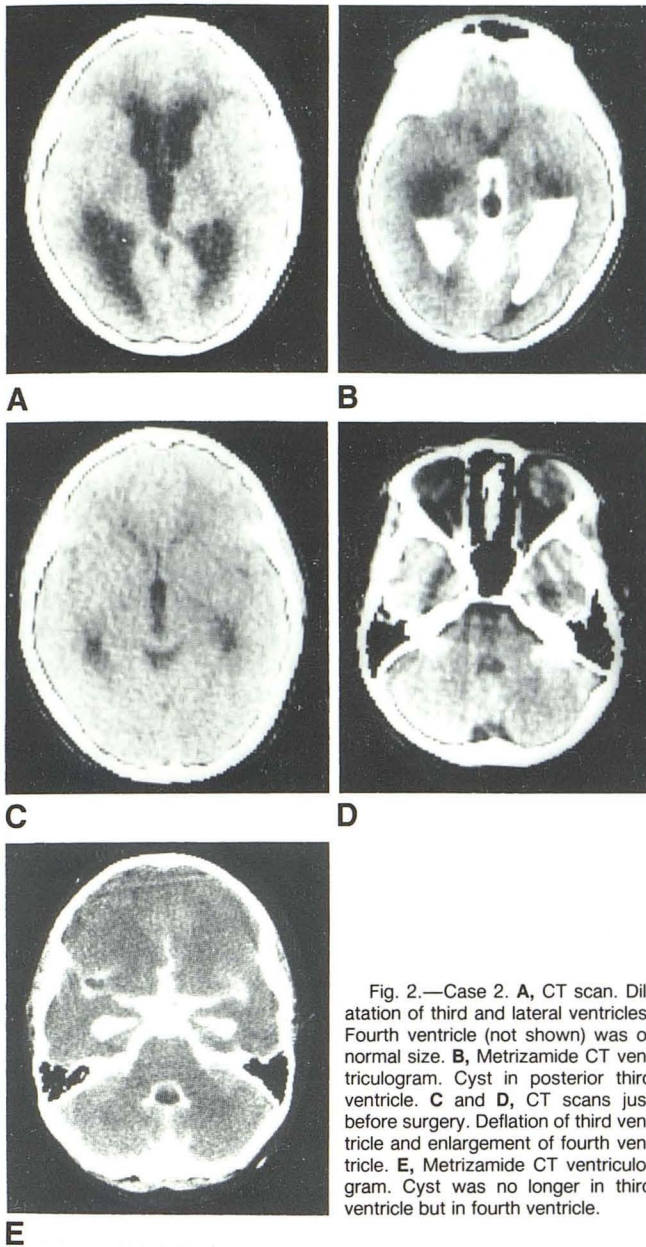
Case 2. A, CT scan. Dilatation of third and lateral ventricles. Fourth ventricle (not shown) was of normal size. B, Metrizamide CT ventriculogram. Cyst in posterior third ventricle. C and D, CT scans just before surgery. Deflation of third ventricle and enlargement of fourth ventricle. E, Metrizamide CT ventriculogram. Cyst was no longer in third ventricle but in fourth ventricle.
